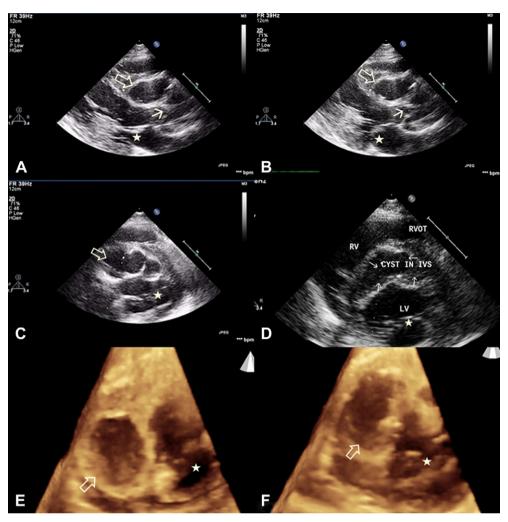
A, B: Parasternal long axis in diastole and systole showing echo-free space [Hollow arrow] at the base of aortic root extending up to mid segment of interventricular septum. There are no vegetations over mitral [Asterisk] or aortic valve [Arrow]. C: Short axis view showing extension of echo-free space [Hollow arrow] in the interventricular septum at the level of mitral valve [Asterisk] bulging into LV cavity. The abscess cavity is well defined with irregular septation intra-cavity. D: Short axis view showing bulging of echo-free space [Multiple arrows] into right ventricle and right ventricular out flow tract. E, F: 3 D echocardiography (TTE) of echo-free space confirmed the diagnosis of myocardial abscess [Hollow arrow]. The cavity of myocardial abscess is well defined and extending deep into interventricular septum up to mid segment at the level of mitral valve [Asterisk].
